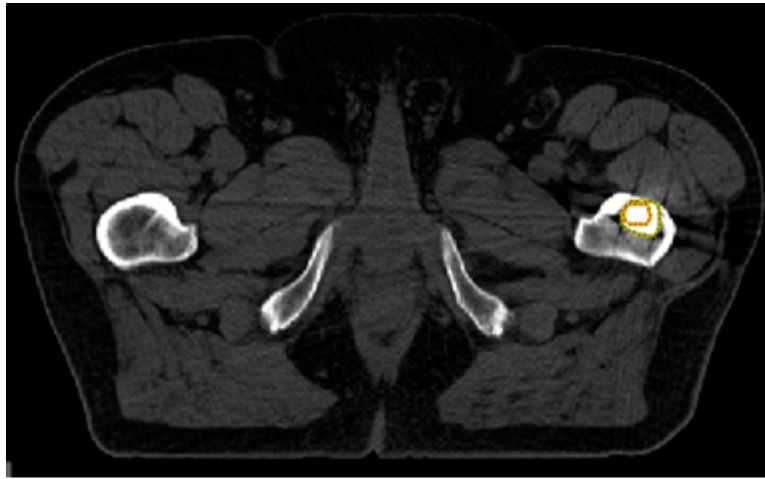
CT slice of a patient in which two contours of the prosthetic stem are compared. The smaller one, in orange, is derived from the 3D model, while the other is the contouring
